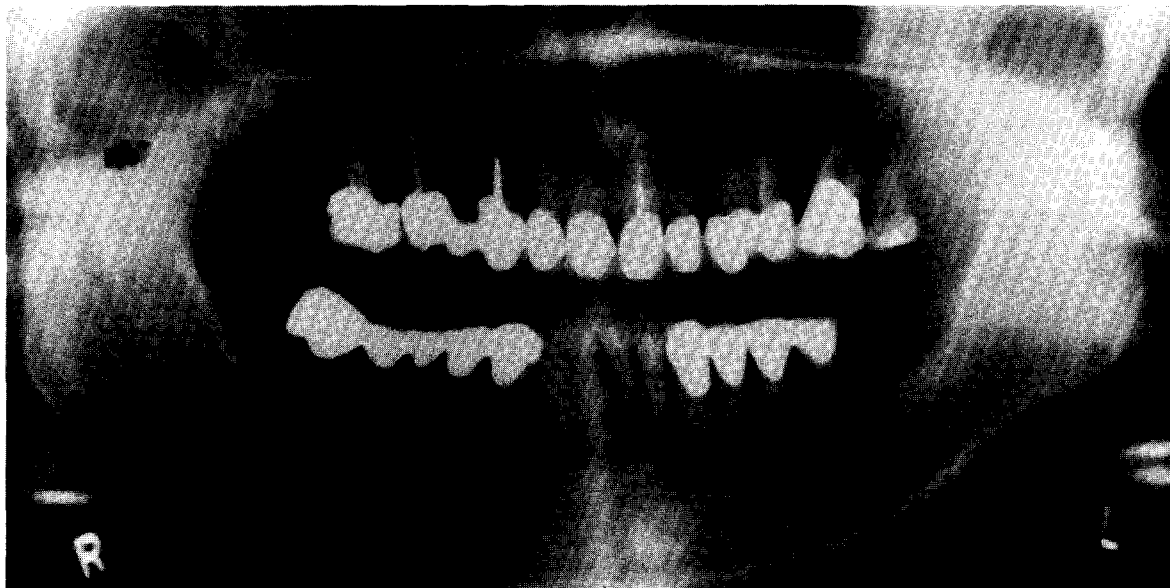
(A). Panoramic radiograph demonstrating destruction of the inferior and posterior walls and adjacent alveolar bone on the right-hand side.
